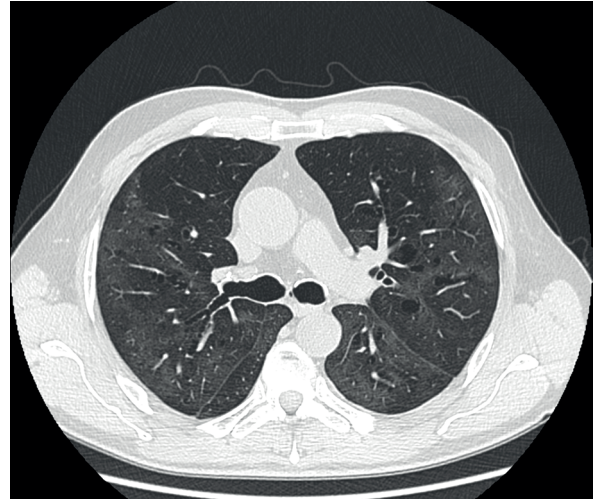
Axial HRCT images of a 70 y.o. convalescent man with mild Covid-19 infection, day 48. Control CT shows multiple, small and diffuse lung cavities in both lungs with persistent peripheral GGOs, reticular pattern and air bubble signs.
